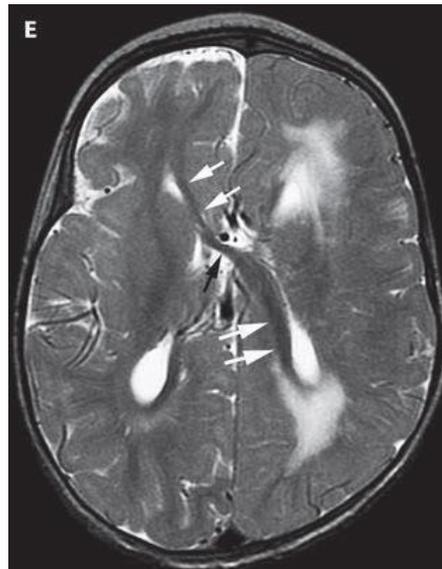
T2-weighted image on the axial plane in which a sigmoidal beam is clearly evident.
